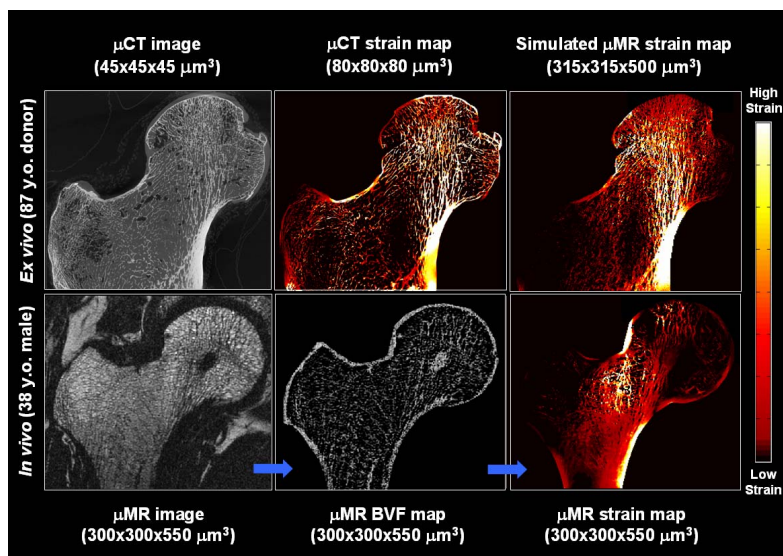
Strain maps corresponding to the stance-phase loading obtained for each data set. Upper row: High-resolution μ CT image and corresponding strain maps derived at different resolutions and noise levels. Lower row: Processing steps necessary for obtaining the strain map related to the *in vivo* μ MR image acquisition (blue arrows).
